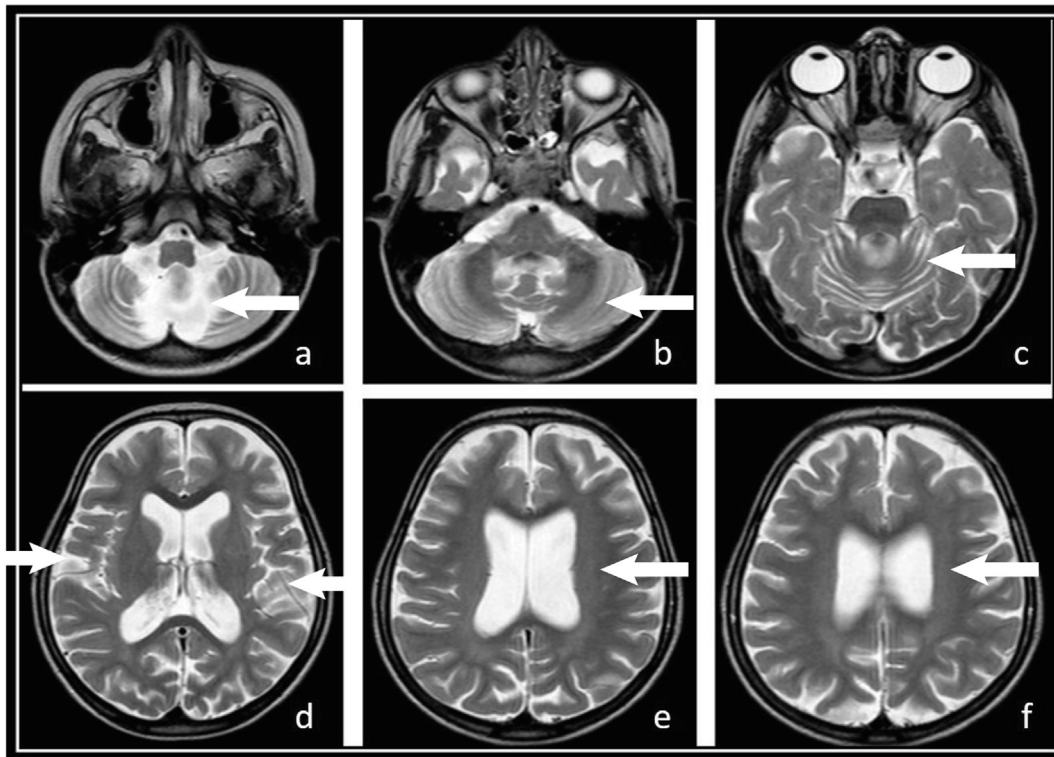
Patient 1 – T2-weighted axial sections from an MRI scan taken 1 year after the onset of symptoms. This scan demonstrates mild to moderate cerebellar (a, b, c) and cerebral (d) atrophy, and linear hyperintensity of central white matter (e, f).
